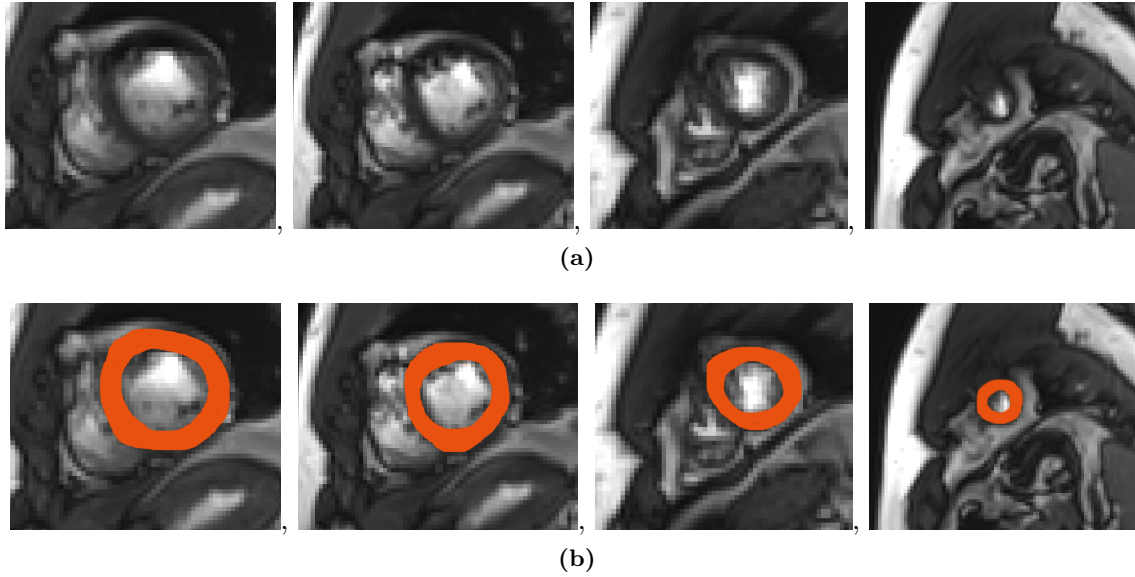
Examples of (a) magnetic resonance images from the CUBIC database and (b) MRI segmentation of the left ventricle.
